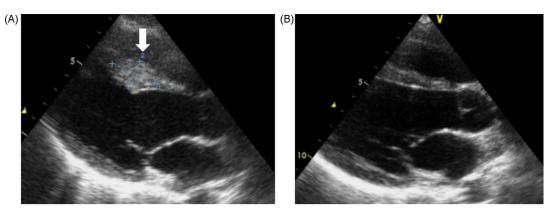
Transthoracic echocardiography. (A) On admission, thickness, granular sparkling appearance, and slightly reduced movement of interventricular septum were recognized (arrow). (B) After the chemotherapy for germ cell tumor in the anterior mediastinum, all abnormalities of interventricular septum disappeared.
